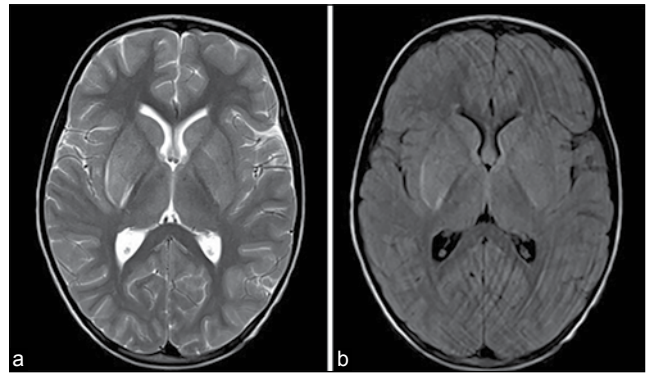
Axial T2/FLAIR MRI images reveal hyperintense lesions involving the bilateral basal ganglia, thalami and cortex in left parieto-occipital region with blurring of grey white matter junction (6a and 6b)
